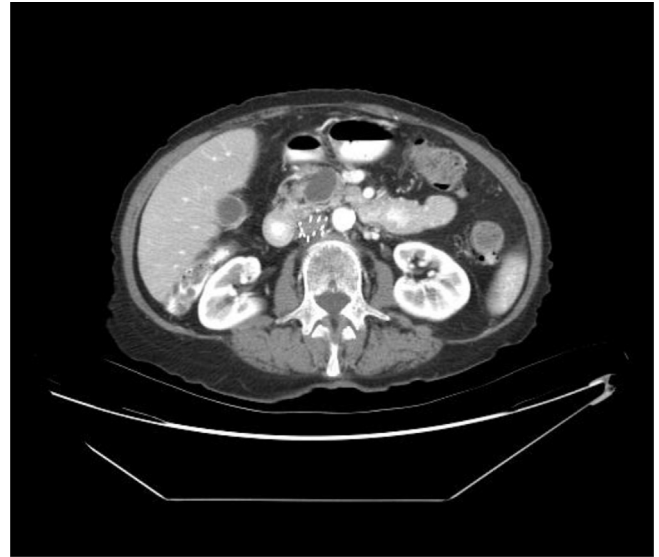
The abdominal CT shown above was in 12/2008 showing 12 struts as compared to the bottom CT abdomen taken on 9/2010 showing only 11 struts.
